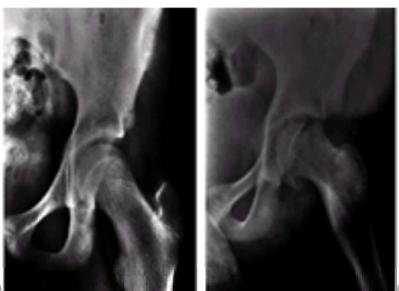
Anteroposterior (A) and frog-leg lateral (B) hip radiographs of a 12-year, 10-month-old girl demonstrate acute epiphyseal displacement. There is no evidence of bone healing or remodeling at the femoral neck.
